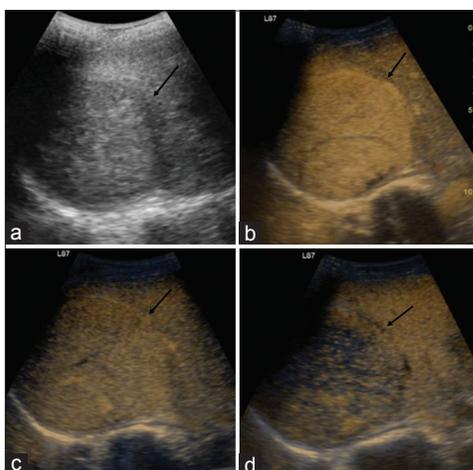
A 36-year-old male - screening ultrasound, multiple large heterogeneously hyperechoic lesions in both lobes of liver, largest in the right lobe in the subdiaphragmatic location (black arrow a). Contrast-enhanced ultrasound is done targeting the larger lesion in the right lobe of the liver showing significant enhancement of lesion in arterial phase at 20 s after contrast injection (black arrow, b) and washout in venous phase at 70 s (black arrow, c) and delayed phase at 180 s (black arrow, d)
